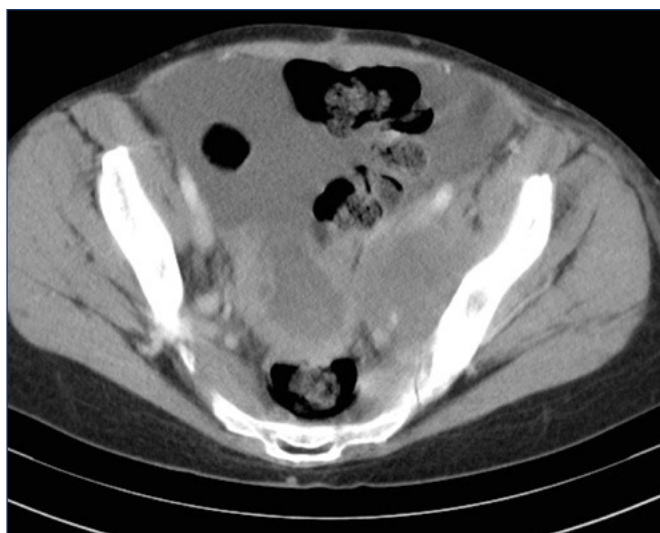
Indirect computed tomographic (CT) venography. Large centrally necrotic midline pelvic mass with nearly confluent left external iliac vein lymph node mass: compare external iliac veins-right normal; left stretched over lymph node.
